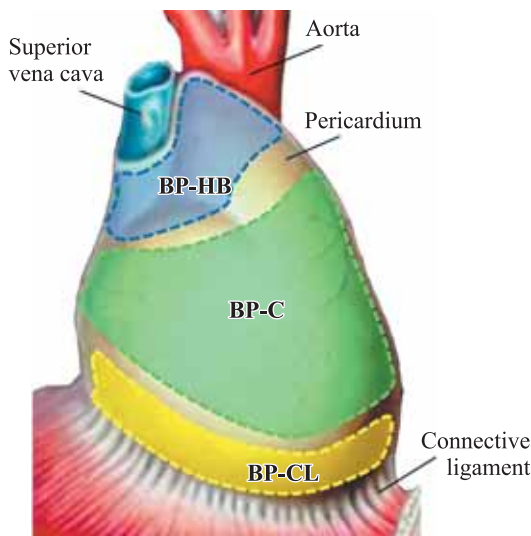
Sampling areas of the studied fragments of the native pericardium. BP-HB, vessel base zone; BP-CT, main part of tissue; BP-CL, ligament base zone
